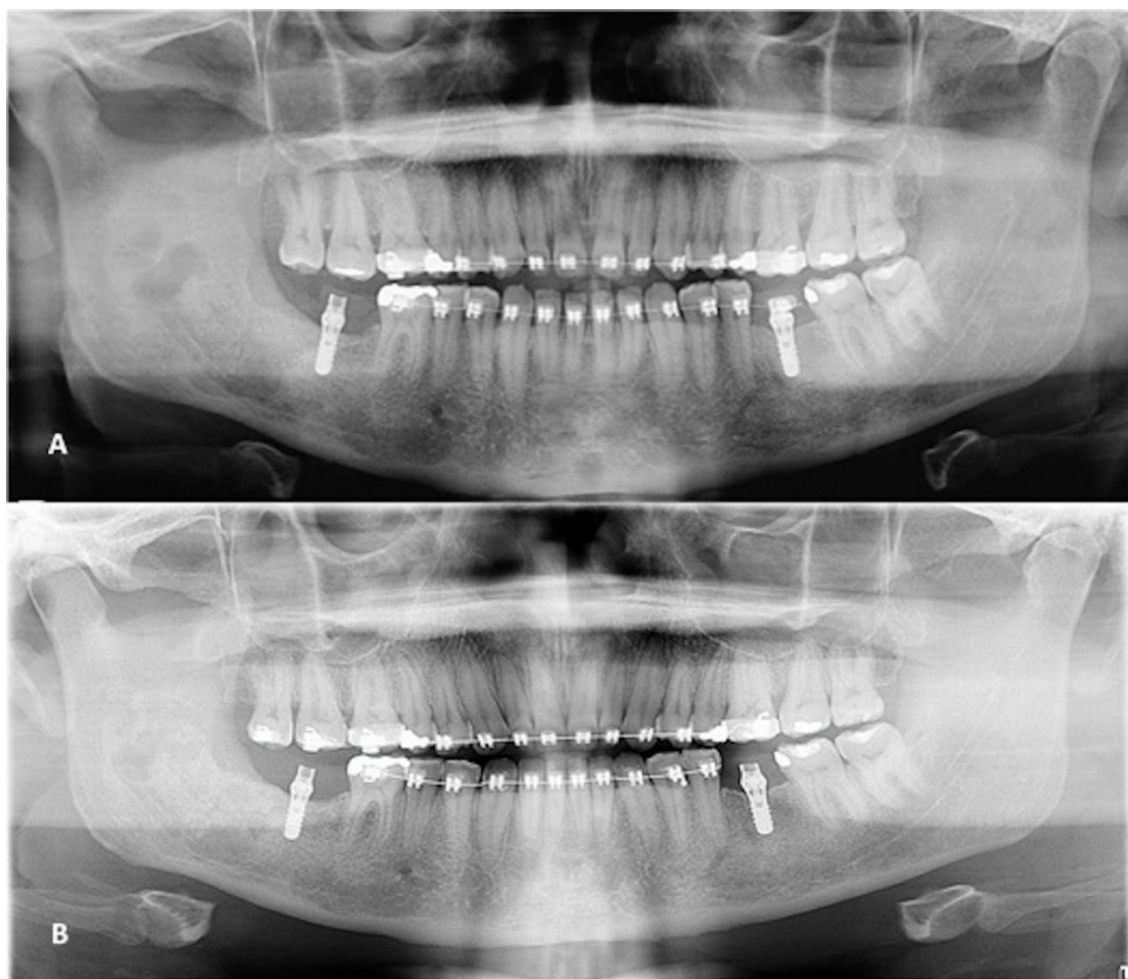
(A) 10-month follow-up panoramic radiograph showing the implant, with no signs of recurrence. (B) 2-year follow-up panoramic radiograph.
